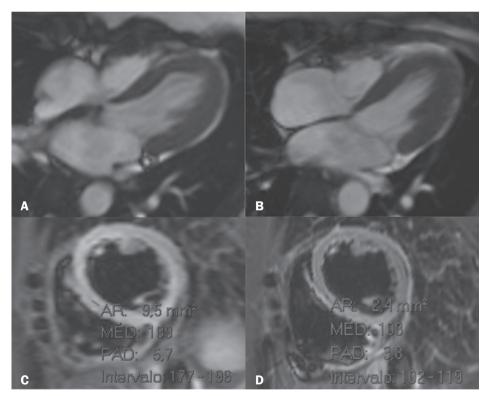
Images of the patient depicted in Figure 10. Cine-SSFP CMR sequences, in four-chamber views (A,B), and T2-weighted sequences with fat saturation (C,D). Images A and C show, respectively, the contractility changes and myocardial edema at the time of diagnosis. Images B and D, acquired one and a half months later, demonstrate the reversal of the findings.
